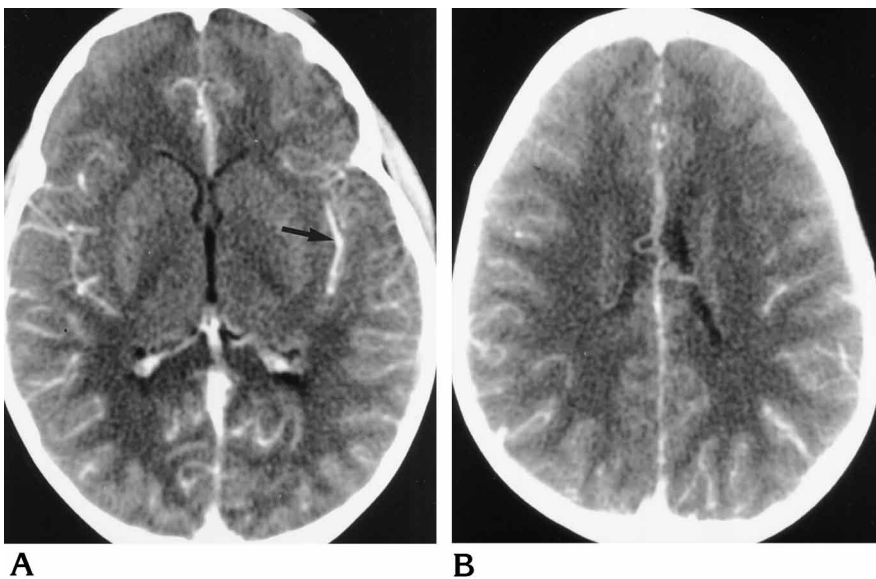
Meningeal enhancement on CT. Axial postcontrast CT sections show enhancement of the subarachnoid space in both cerebral hemispheres, particularly at the level of the left sylvian fissure (*arrow*). However, some of the enhancement may represent prominent vessels. At presentation, this patient was posturing and unresponsive and died during hospitalization. Autopsy showed meningitis with swollen and congested vessels in the leptomeninges and neuronal necrosis in the hippocampi.
